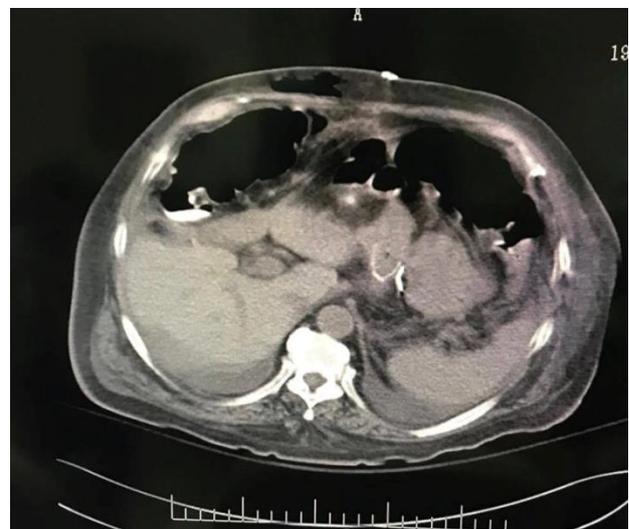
A computed tomography scan showed fluid in Morison pouch.
